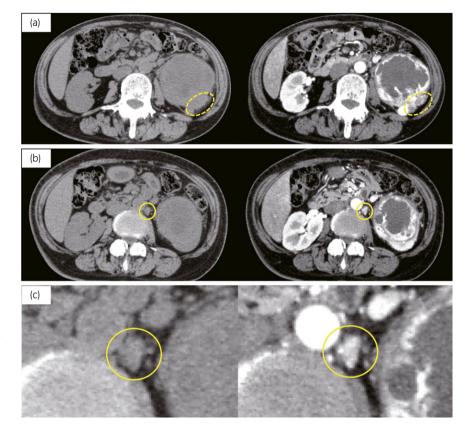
Noncontrast (left side) and contrastenhanced (right side) CT shows a well-enhanced tumor 8 cm in diameter with central necrosis at the lower pole of the left kidney. Dashed yellow circles indicate well-enhanced small nodules adjacent to the tumor (a). Well-enhanced paraaortic LNs are also indicated by yellow circles (b). Within the LNs, no findings of low-density area which indicates a fat component.
